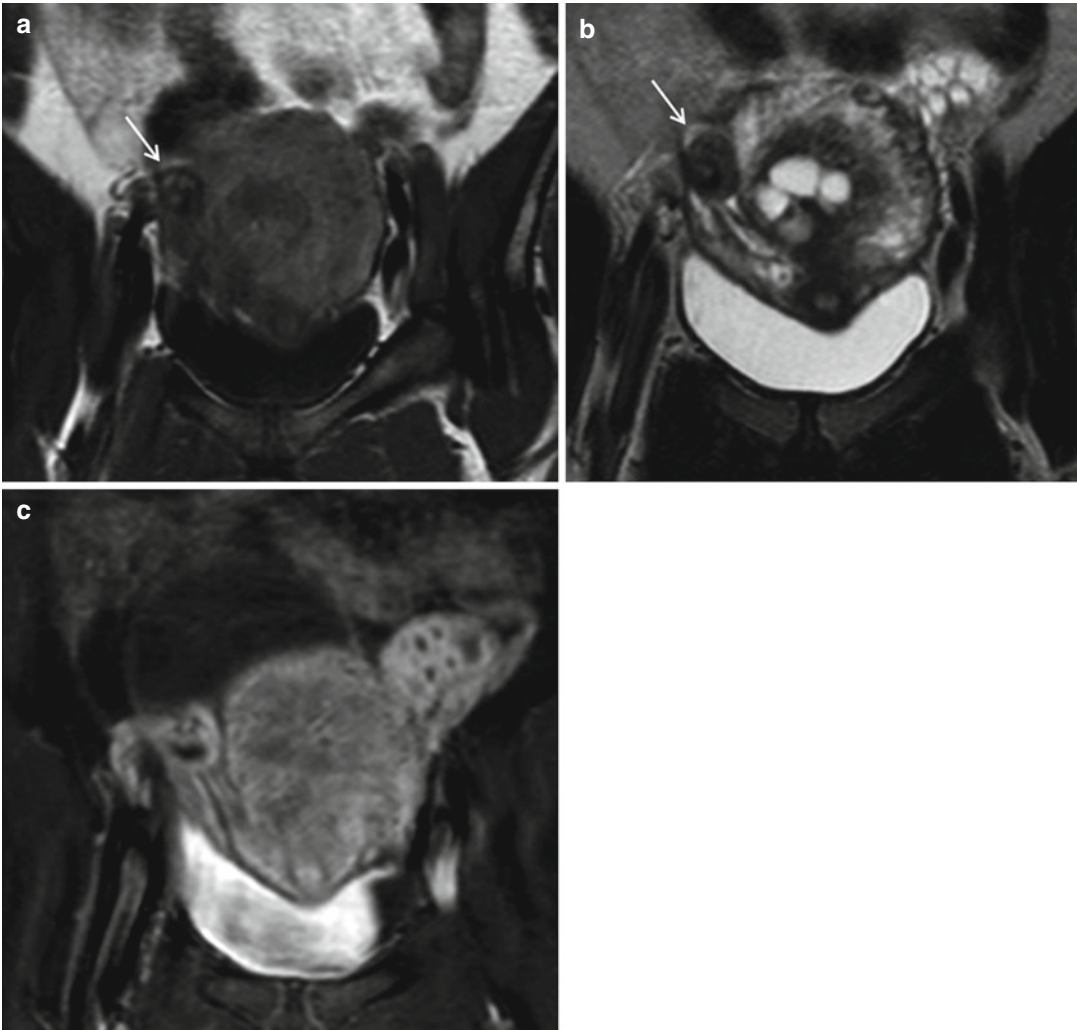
MRI in a 7-year-old girl with surgically confirmed twisted ovarian teratoma. (a, b) Coronal T1- and T2-weighted images show a heterogenous solid mass with cystic areas inside and associated twisted pedicle. (c)
